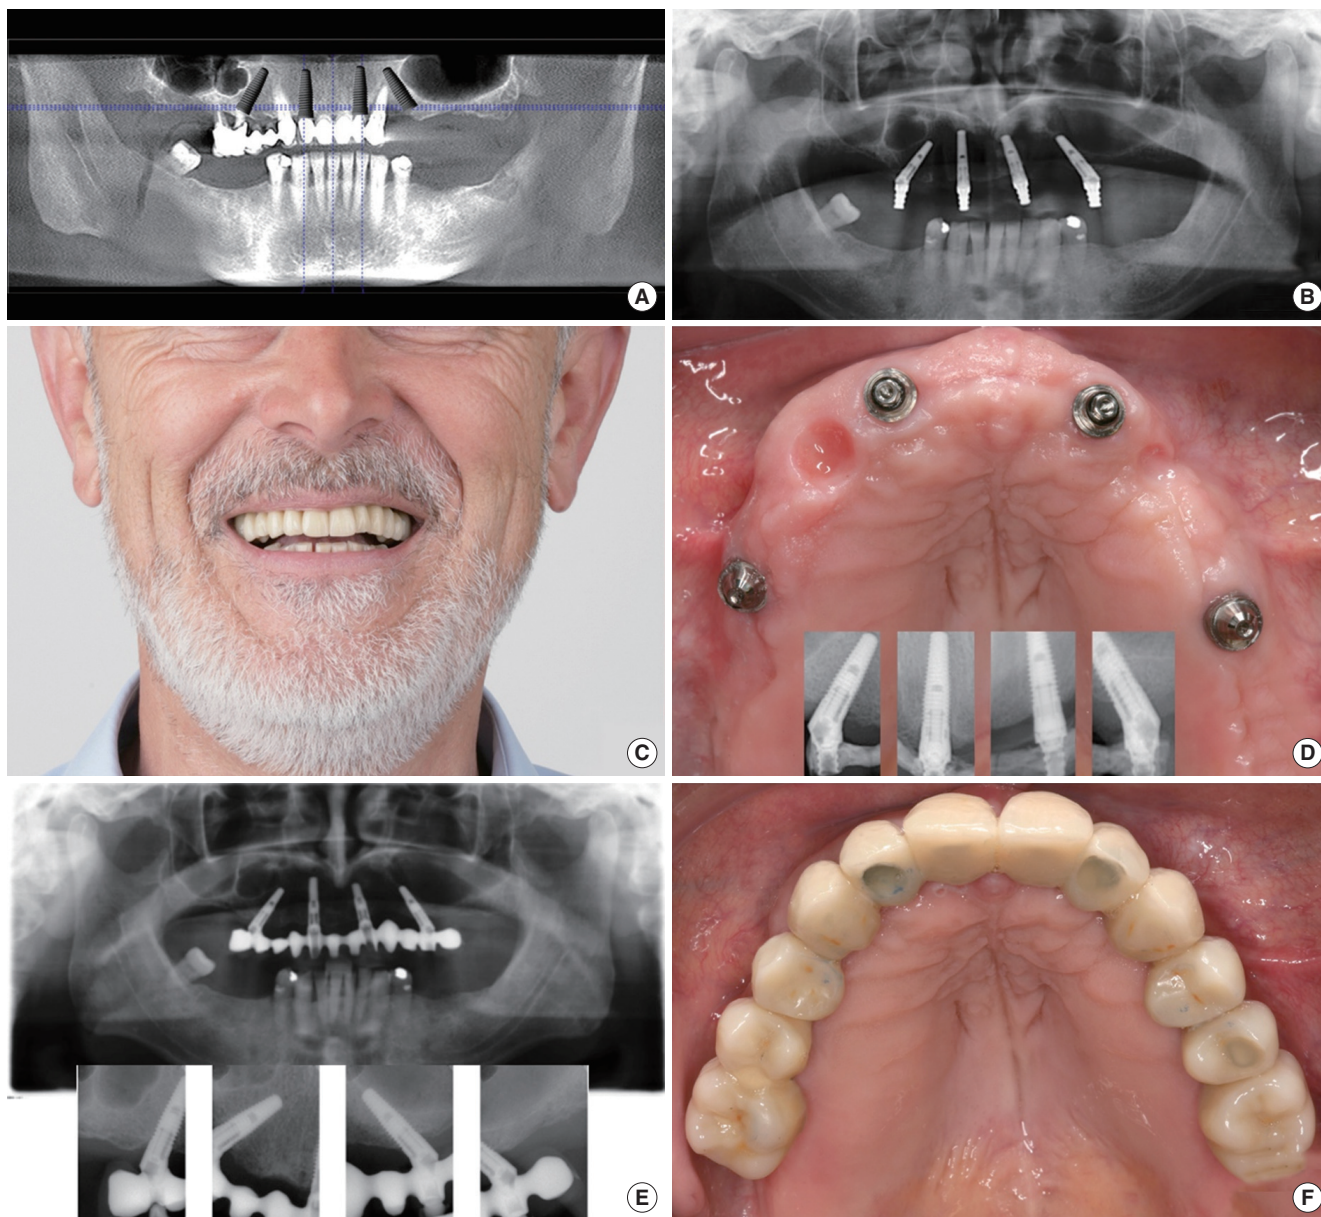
Implant rehabilitation of the completely edentulous maxilla according to the All-on-4 (Nobel Biocare, Gothenburg, Sweden) flapless protocol. (A) Pre-operative planning procedure using cone-beam computed tomographic scans, (B) postoperative X-ray with impression copings and angulated multiunit abutments on tilted distal implants, (C) immediate temporary fixed restoration delivered at the day of surgery, (D) pictures and x-rays at final prosthesis delivery, and (E, F) 5 years after implant placement.
